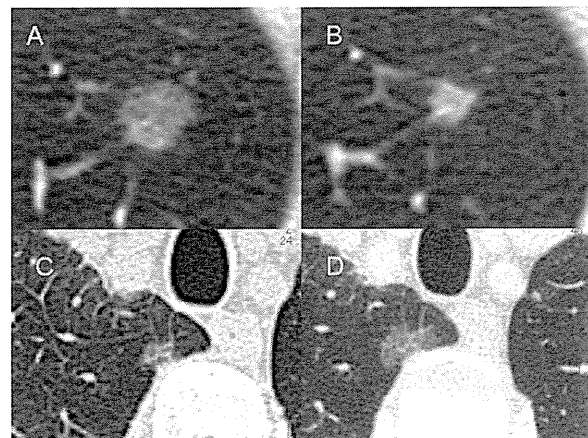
A-B, A nonsolid nodule showing shrinkage in a short period. C-D, A nonsolid nodule showing growth. Interval size changes between follow-up CT scans were measured using the same or nearest level of high-resolution CT (HRCT) image that was determined by synchronizing the anatomic structure around the nodule. A, Nonsolid nodule in the left upper lobe, measuring 10 mm in diameter at the first HRCT scan. B, After 3 mo, this nodule showed shrinkage to a polygonal shape. C, Nonsolid nodule in the left upper lobe, with a history of lung cancer. D, After 3 y and 5 mo, this nodule showed growth by 6 mm.
